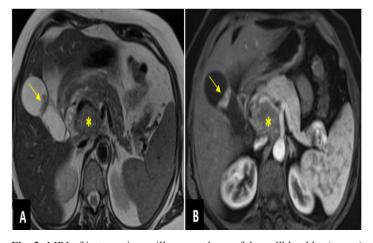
MRI of intracystic papillary neoplasm of the gallblpadder (arrow) associated with pancreatic ductal adenocarcinoma (*) on T2 (A) and T1 with injection (B) sequences.
